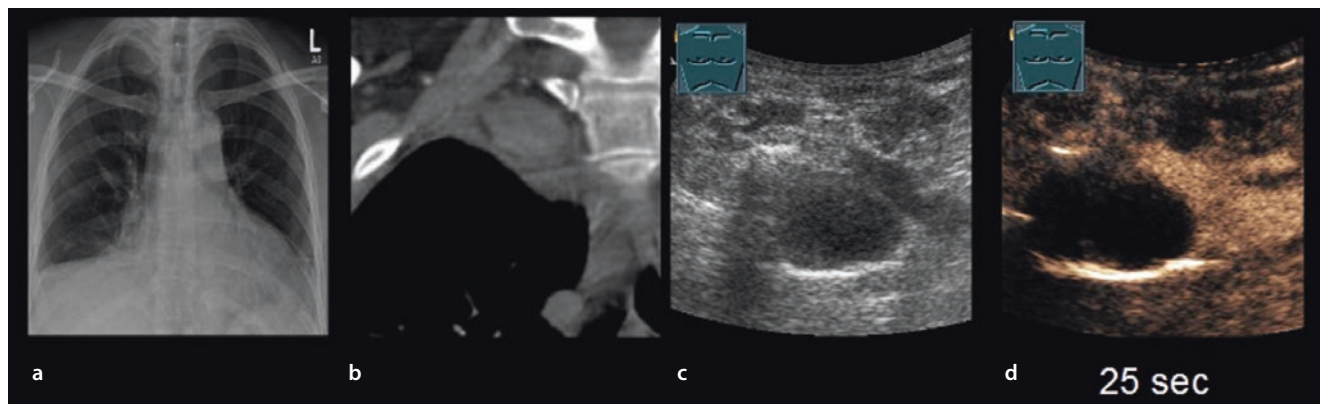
Man with a space-occupying lesion in the right supraclavicular fossa, which is seen on conventional X-ray a as well as CT b. The patient's medical history mentions the insertion of a central venous access on the right side. c B-mode ultrasonography shows that
